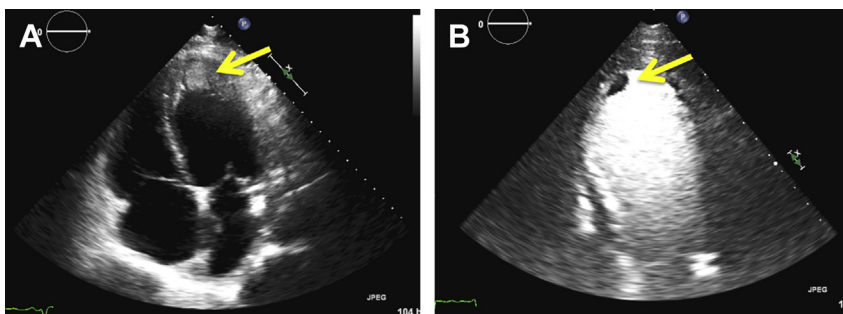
(A) A 70-year-old man with a history nonischemic cardiomyopathy presented with acute decompensated HF. Transthoracic echocardiography demonstrated apical thrombus (arrow). (B) A 61-year-old man with a history of ischemic cardiomyopathy and acute lymphocytic leukemia presented in septic shock. Hospital course was complicated by left frontal ischemic stroke. Contrast transthoracic echocardiography demonstrated apical thrombus (arrow).
